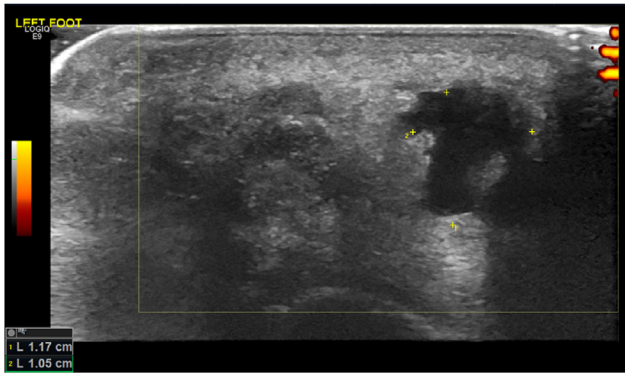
Ultrasound picture.
